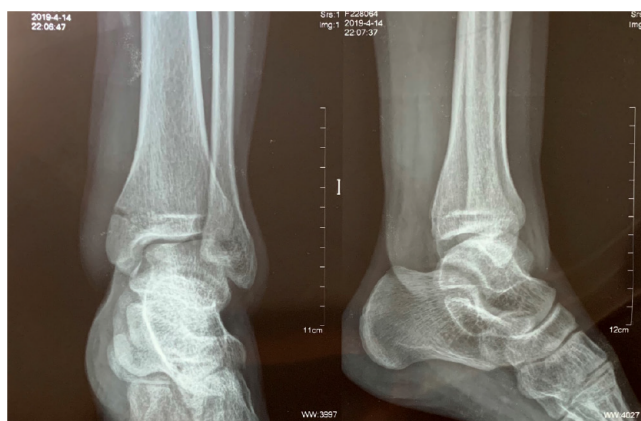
Left ankle radiographs (from another hospital) of anteroposterior and lateral views showing medial malleolar fracture.
